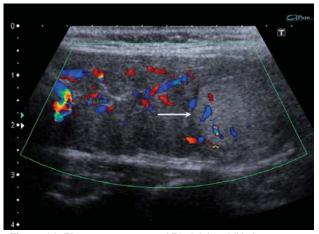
Biopsy proven case of Riedel thyroiditis in a 40 year old male with a fixed stony hard thyroid. Ultrasound shows diffuse enlargement with fibrous septa radiating outwards from the thyroid into the surrounding tissue.
